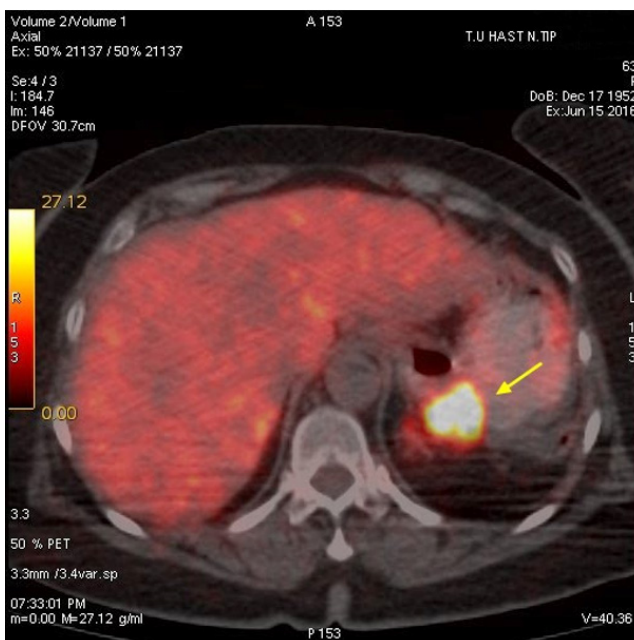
The lesion of stomach wall (Transaxial PET CT Fusion)
